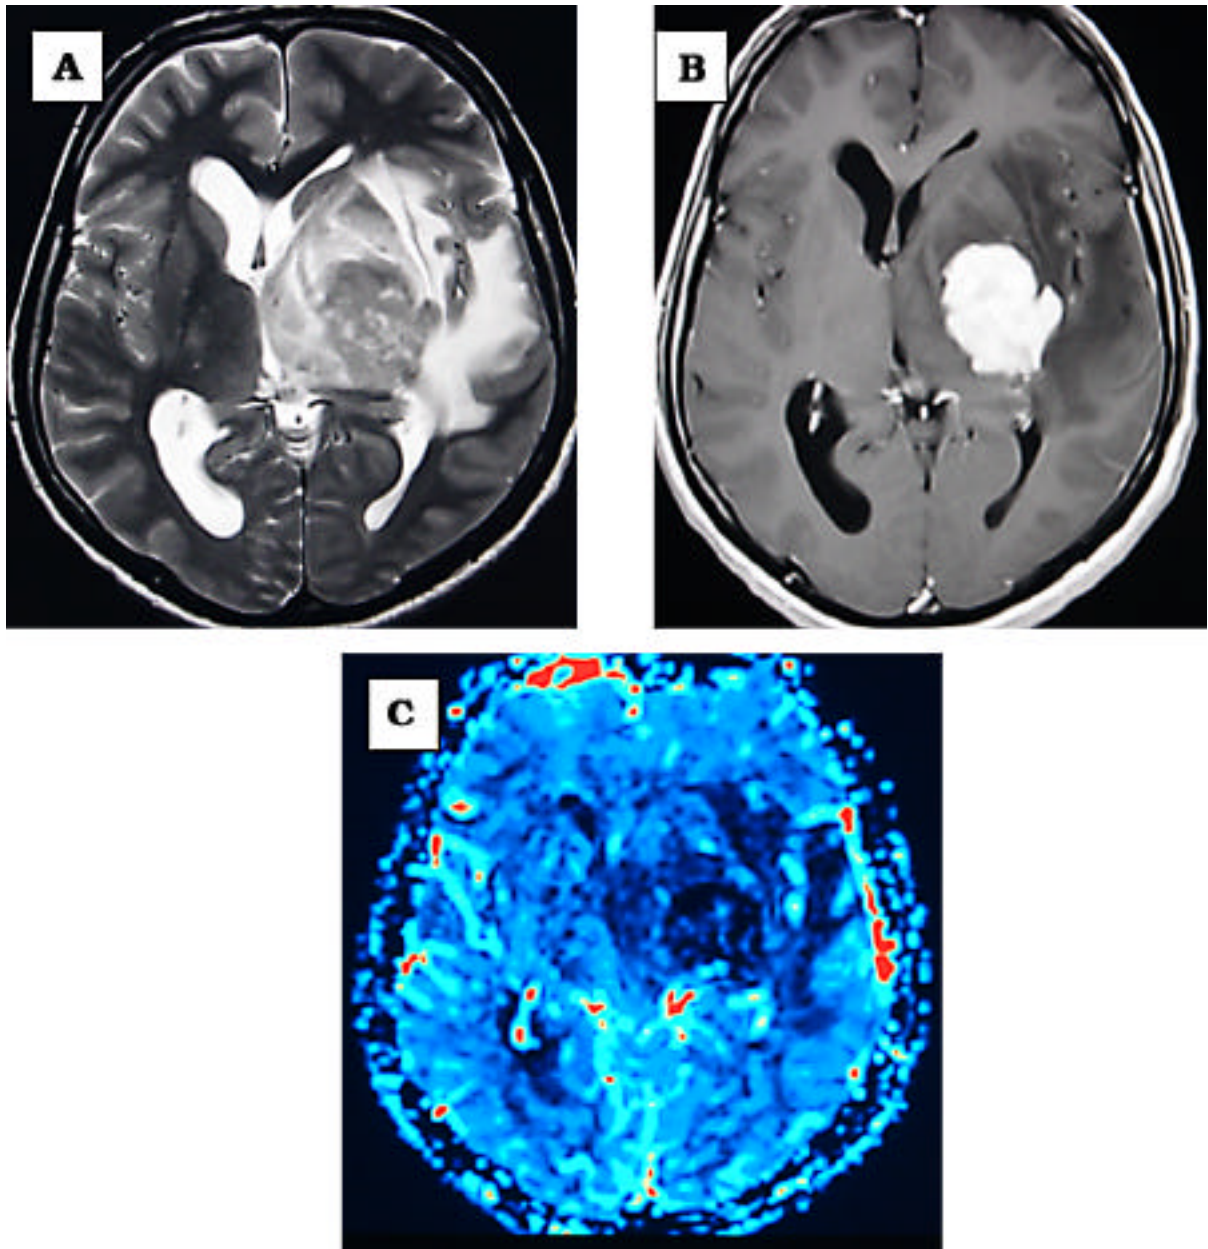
A: T2-weighted axial MR scan. B: T1-weighted axial post-contrast scan. C: MR perfusion scan. There is a T2 hypointense mass in the left basal ganglia with intense enhancement after contrast scan, and reduced rCBV on perfusion images (black arrow).
